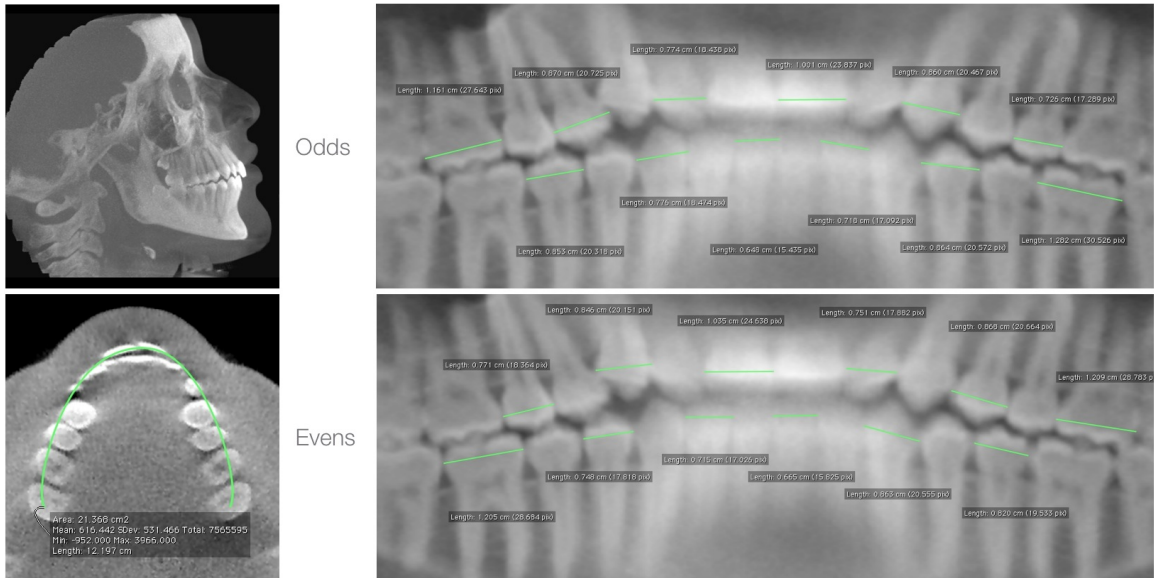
Method 4: CBCT Simple Pano - OsiriX.
